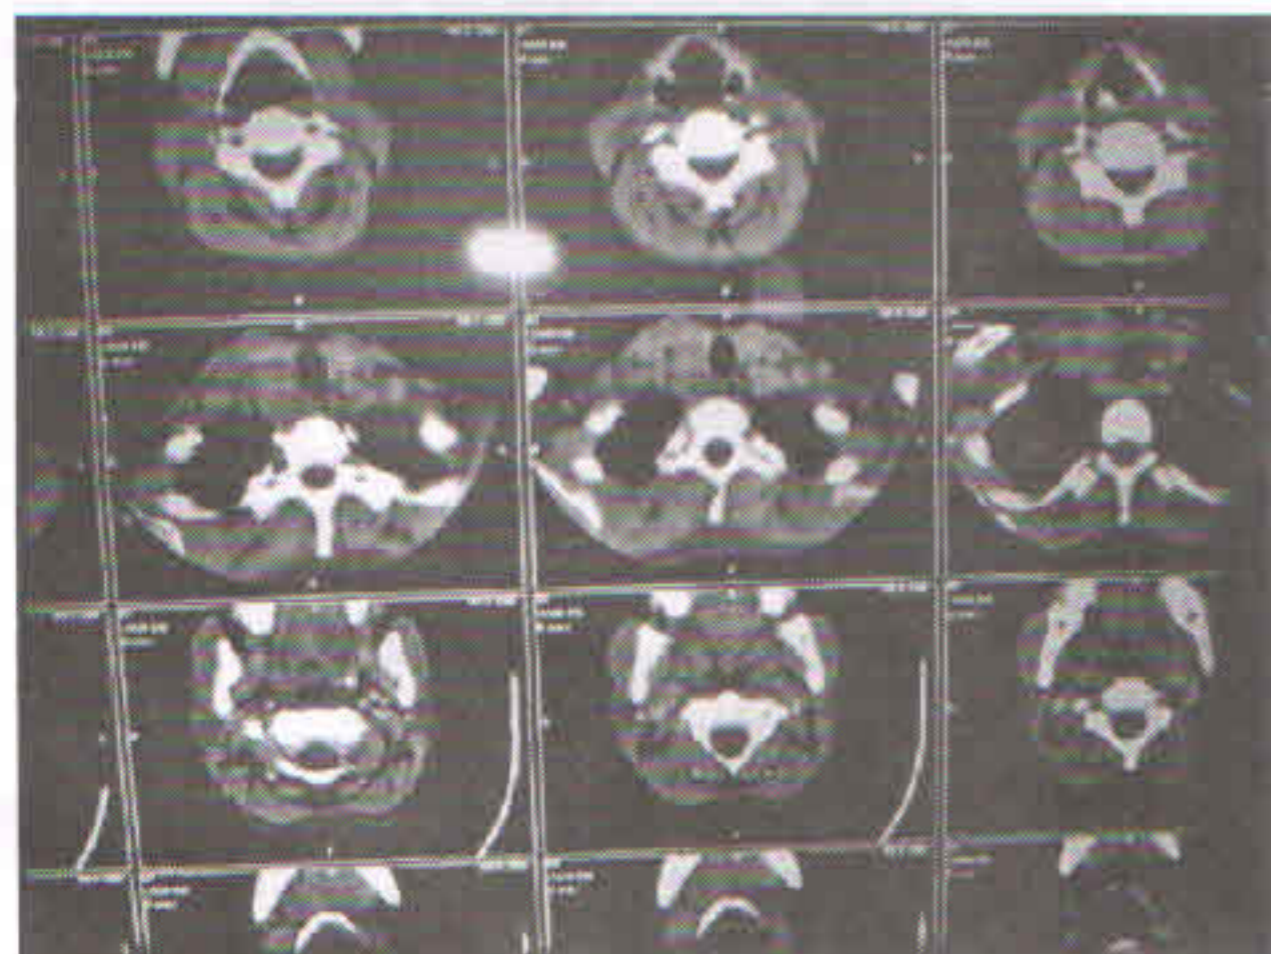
CT Scan neck shows hypodense lesion near inferior pole of right thyroid suggestive of parathyroid adenoma
